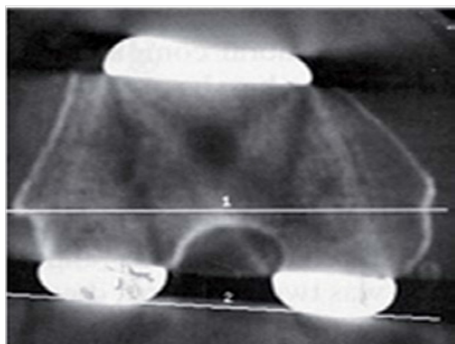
Internal rotation of femoral component compared to surgical epicondylar line shown in CT.
